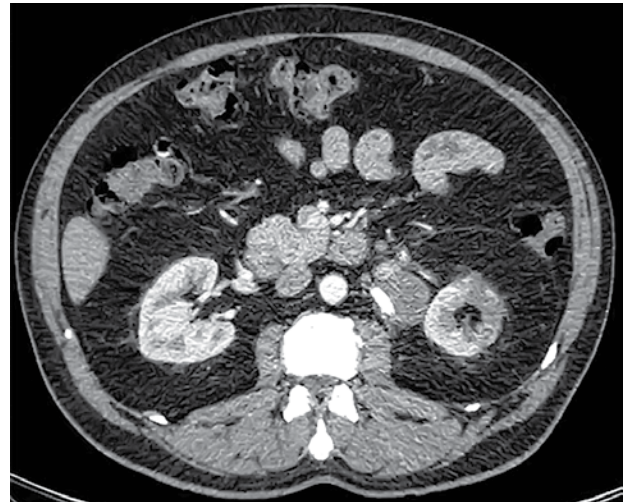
Follow-up computed tomography angiography three months after intervention indicates successful aneurysm exclusion, with blood flow preserved in the left renal artery. The left kidney is smaller and has areas of infarction.
